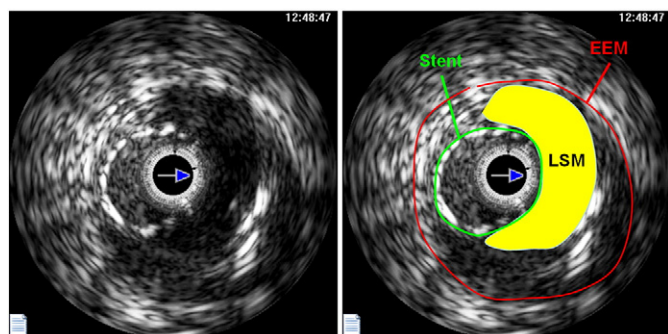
The gray-scale intravascular ultrasound image of late stent malapposition (LSM) at 12 months after paclitaxel-eluting stent implantation. EEM: external elastic membrane.
